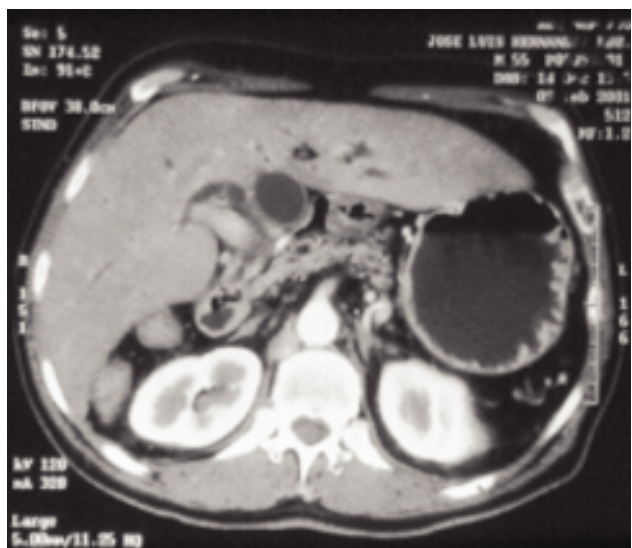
Abdominal CT scan: Hepatomegaly. The left lobe extends up to the hypochondrium. Preduodenal portal vein location, inverted superior mesenteric vessels, continuity of the vena cava with the acigos vein and absence of the intrahepatic vena cava.
